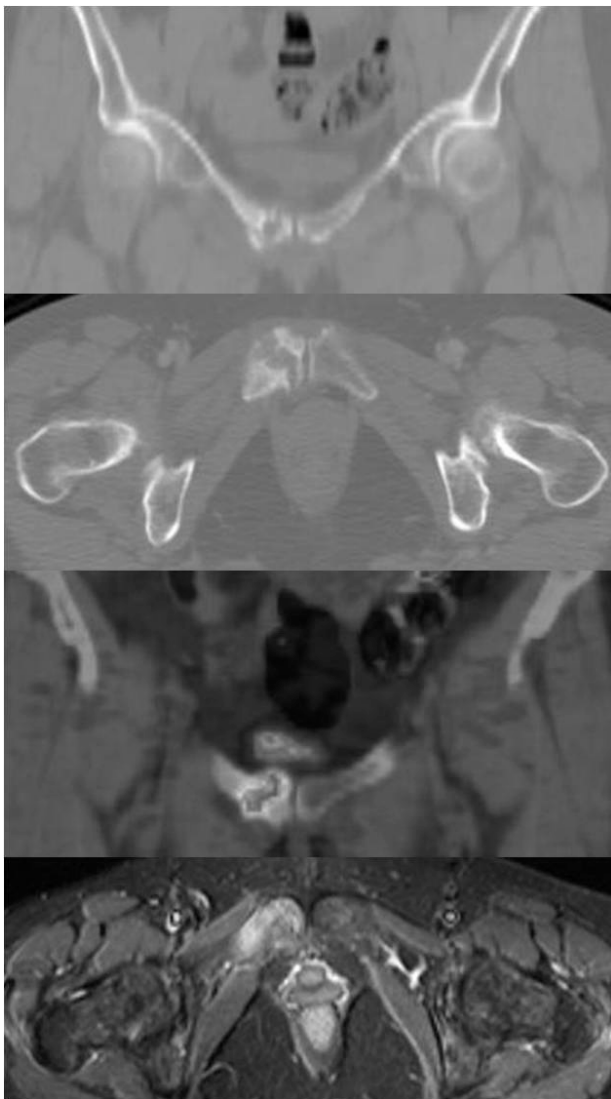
CT, CT-PET and MRI of the pelvis taken three months after pain onset, showed an evident osteolysis of the right ileopubic ramus.
